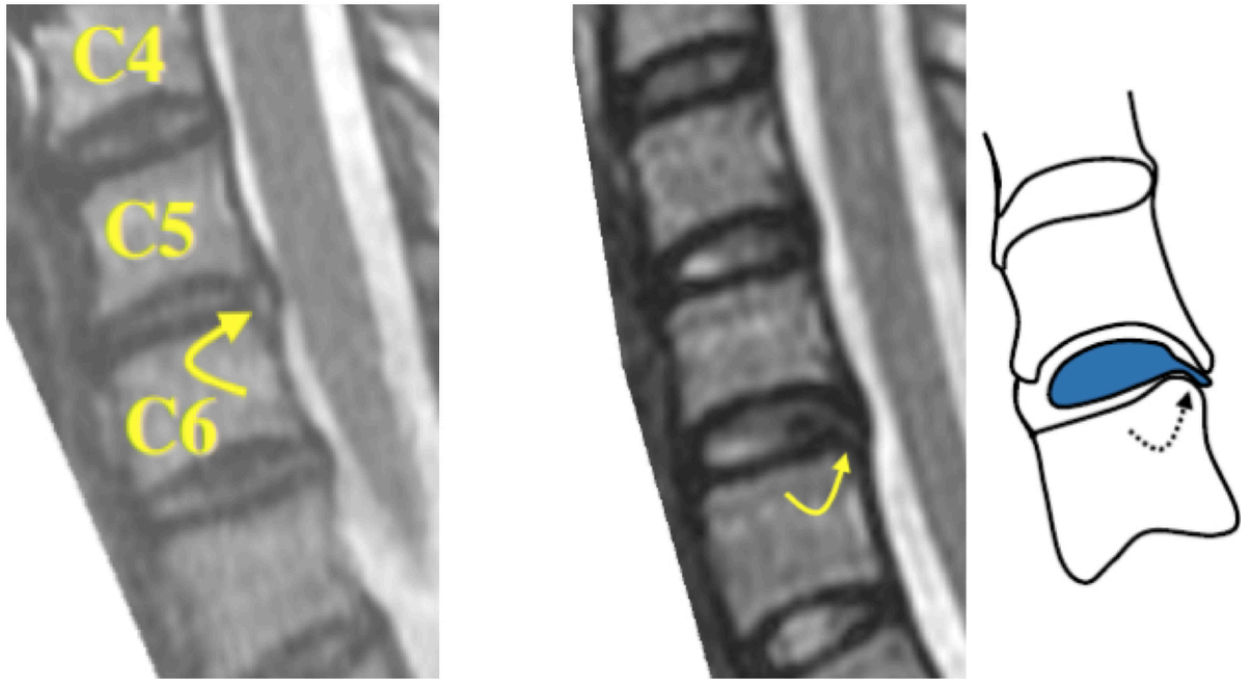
a) HIZ at level C5-C6 b) Annular fissure at level C6-C7. Sagittal T2-weighted images.
